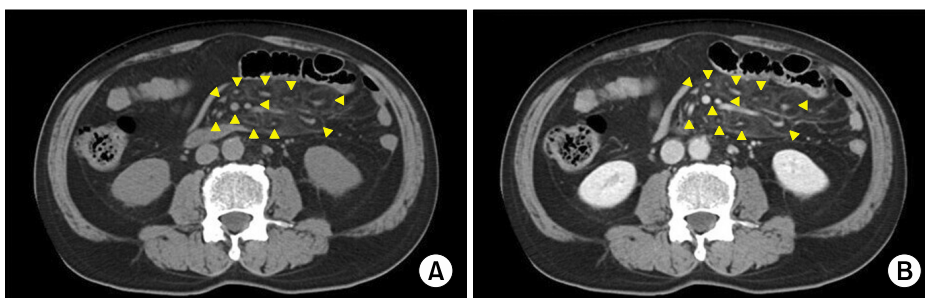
Plain and contrast-enhanced abdominal computed tomography (CT) revealing a mesenteric mass with high attenuation and hypoattenuated fat surrounding the mesenteric vessels, the so-called “fat ring sign” (arrowheads) (A: plain CT, B: contrast-enhanced CT).
